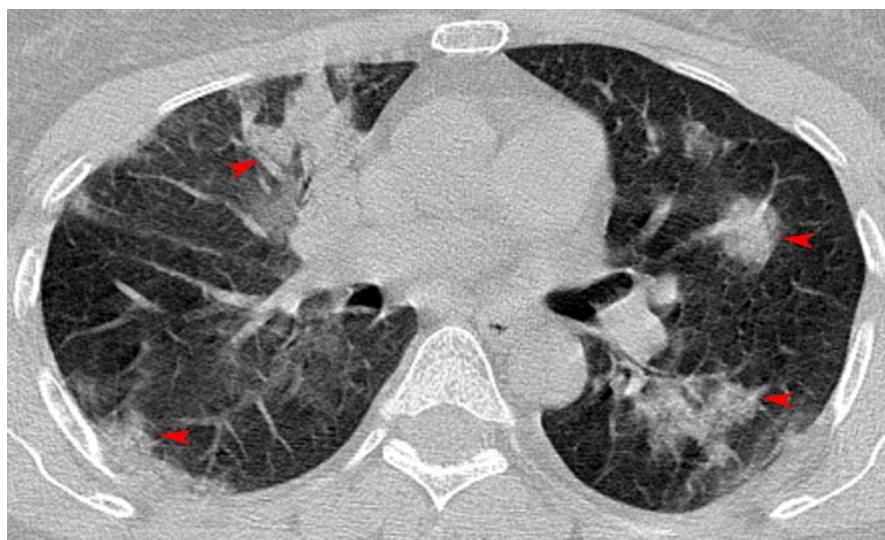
Unenhanced chest CT of a 38-year-old woman with newly diagnosed hypertrophic cardiomyopathy with confirmed COVID-19 pneumonia. Mild dilatation of the pulmonary arterial branches (arrowheads) traversing the region of segmental peripheral ground-glass density is evident.
